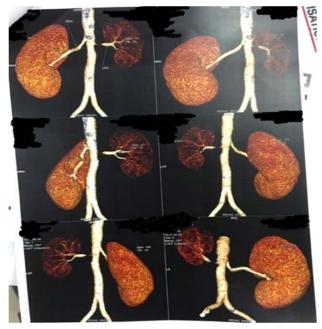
CT Angiogram of abdominal aorta
